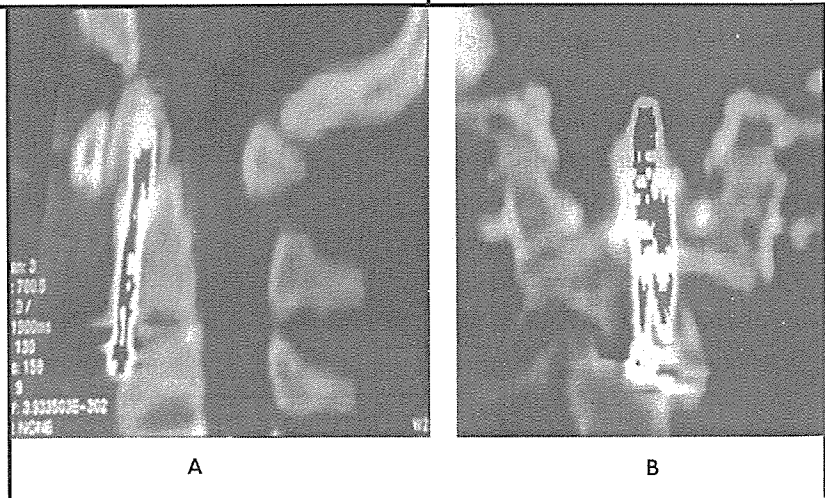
Repositioned odontoid fracture by transodontoid screw fixation demonstrated by CT scan.
